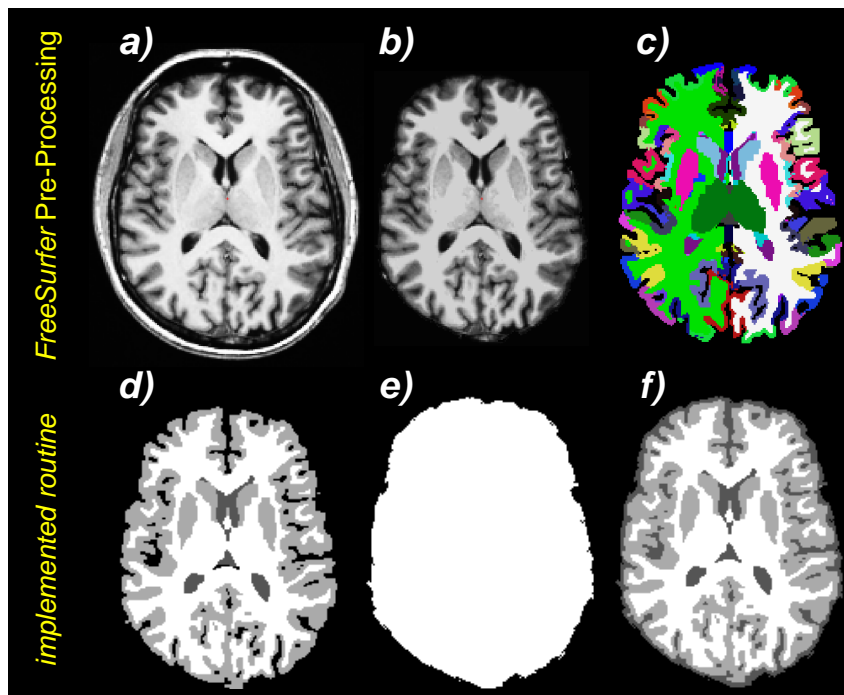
Steps during the segmentation process using a 3D high resolution T_1 weighted whole brain MRI data set: (a) transverse slice of an T_1 weighted MRI volume, (b) removal of non-brain structures, (c) segmentation of brain volume into separated cortical areas (represented by different RGB values), (d) classification of segmented cortical areas with respect to their assignment to GM, WM and CSF, (f) additional assignment of non classified CSF areas by using a brain mask (e).
